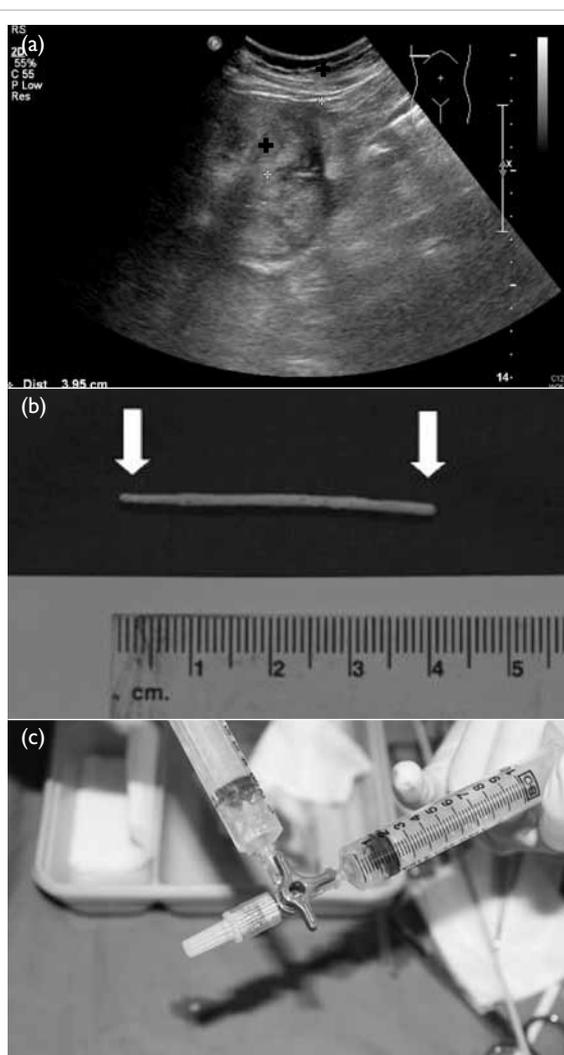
(a) The length of the biopsy path starting from the organ capsule to the target region is measured on ultrasonography. (b) A strip of Gelfoam of the same length with a width of 2 mm is cut from a sheet of Gelfoam. It is then rolled into a rod-like structure (torpedo). (c) Macerating the suspension of Gelfoam with two syringes and a 3-way stopcock allows further decrease in size of the pledgets
